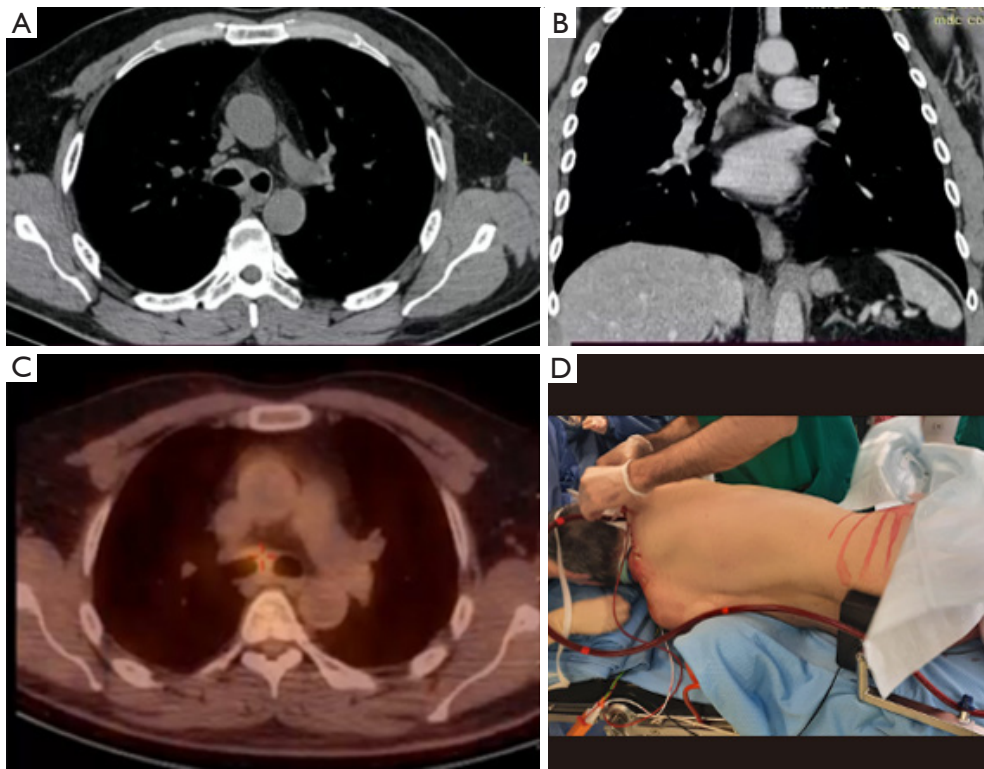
Pre-operative chest-CT scan (A,B), 18-fluorodeoxyglucose-positron emission tomography (C) and lateral decubitus position (D) after the insertion of VV-ECMO cannulae of the case 9. CT, computed tomography; VV-ECMO, veno-venous extra-corporeal membrane oxygenation.
